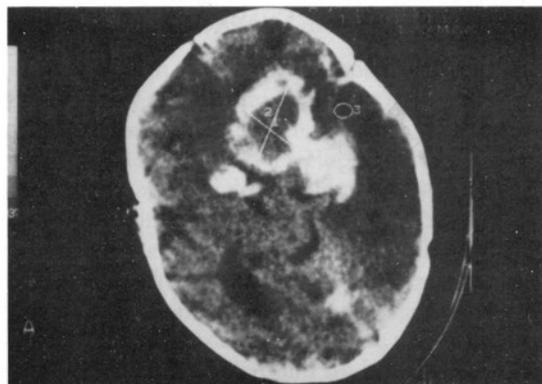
Contrast enhancement CT scan showing a mass in the right middle fossa spreading out to the right anterior fossa with surrounding brain oedema. Necrosis also seen in the middle of the mass.
